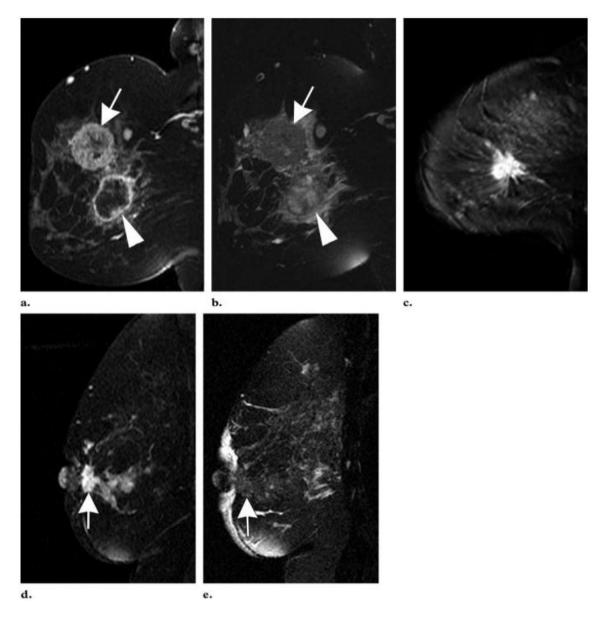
Malignant features. (a) Contrast-enhanced T1-weighted fat-saturated GRE image shows two masses in left breast of a 44-year-old woman, one with thin rim like enhancement at the 4-o'clock position (arrowhead) and the other with heterogeneous enhancement and enhanced internal septa at the 2-o'clock position (arrow). (b) T2-weighted fat-saturated image shows low signal intensity in the portions of the masses that appeared enhanced in a. A central region of necrosis in the mass at the 4-o'clock position shows increased internal T2-weighted signal intensity. The masses proved to be poorly differentiated ductal carcinoma with necrosis and signet ring cell features. (c) Contrast-enhanced T1-weighted subtraction image from a 42-year-old woman
